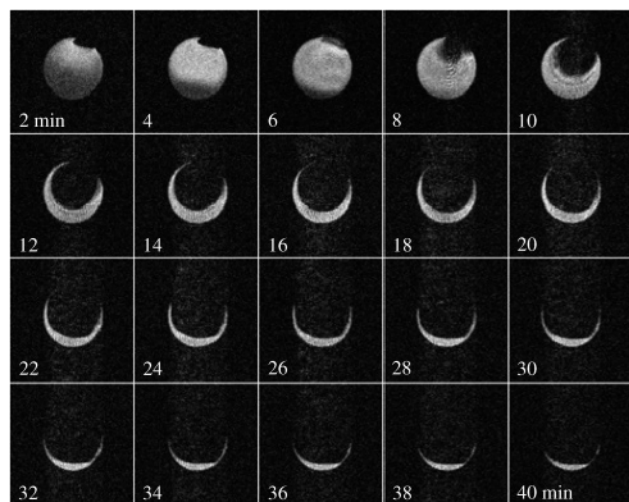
Time sequence of magnetic resonance images of a blood clot in an axial cross-section during dissolution process. Flowing blood in the channel cannot be seen in images as it moves out of the imaging plane before signal acquisition.
